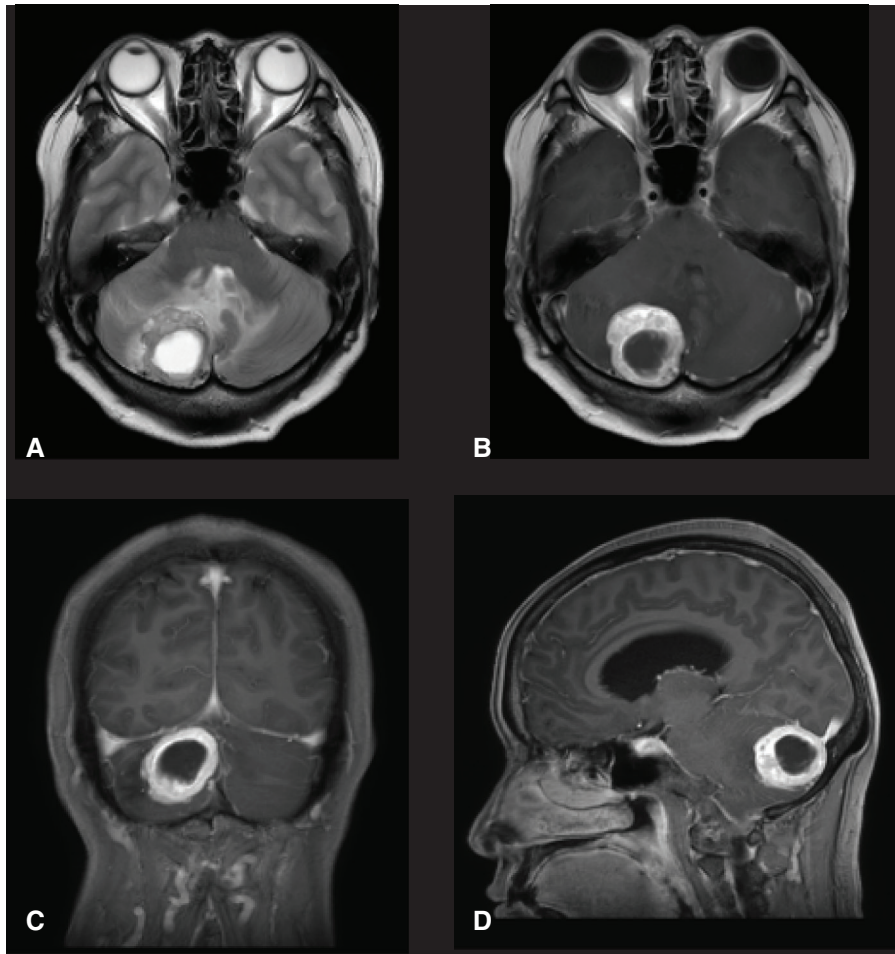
MRI before treatments. (A) T2WI showed the cystic tumor with perifocal edema in the right cerebellum. (B–D) T1WI revealed an enhanced lesion mimicking solid hemangioblastoma. T1WI: T1-weighted image; T2WI: T2-weighted image
